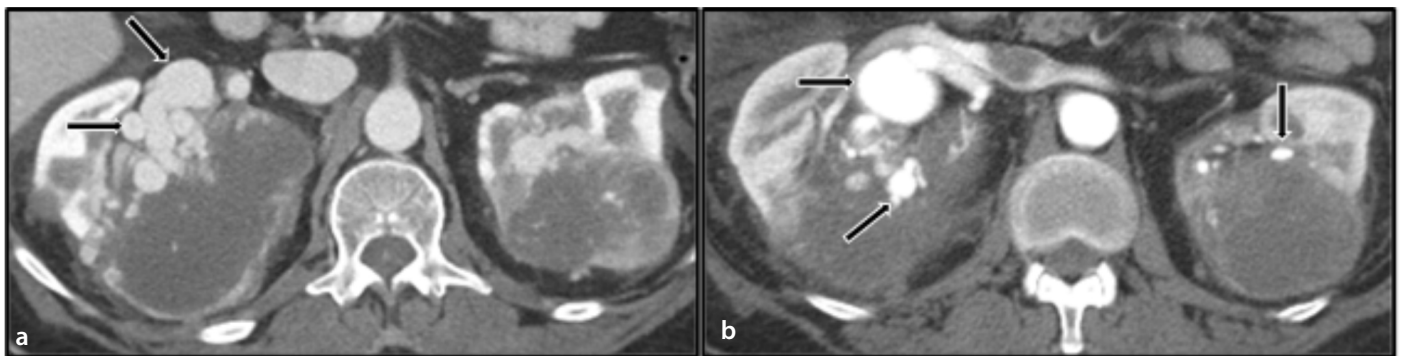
Axial CT images (a, b) demonstrate bilateral renal cell carcinomas with invasion of the renal hila. Multiple bilateral dilated vessels and aneurysms are present in the renal hilar regions (black arrows). Renal cell carcinoma is commonly associated with a variety of vascular anomalies, including renal artery aneurysms and arteriovenous fistulas. CT, computed tomography.
